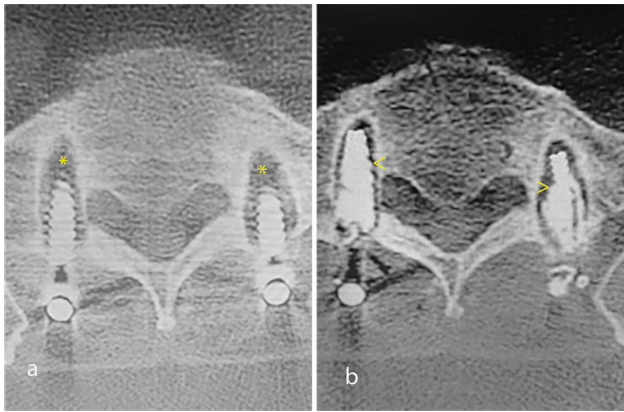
The computed tomography scans were used to evaluate if the proper filling was acquired (*bone loosening around the screw; > the gap was filled with polymethylmethacrylate).
